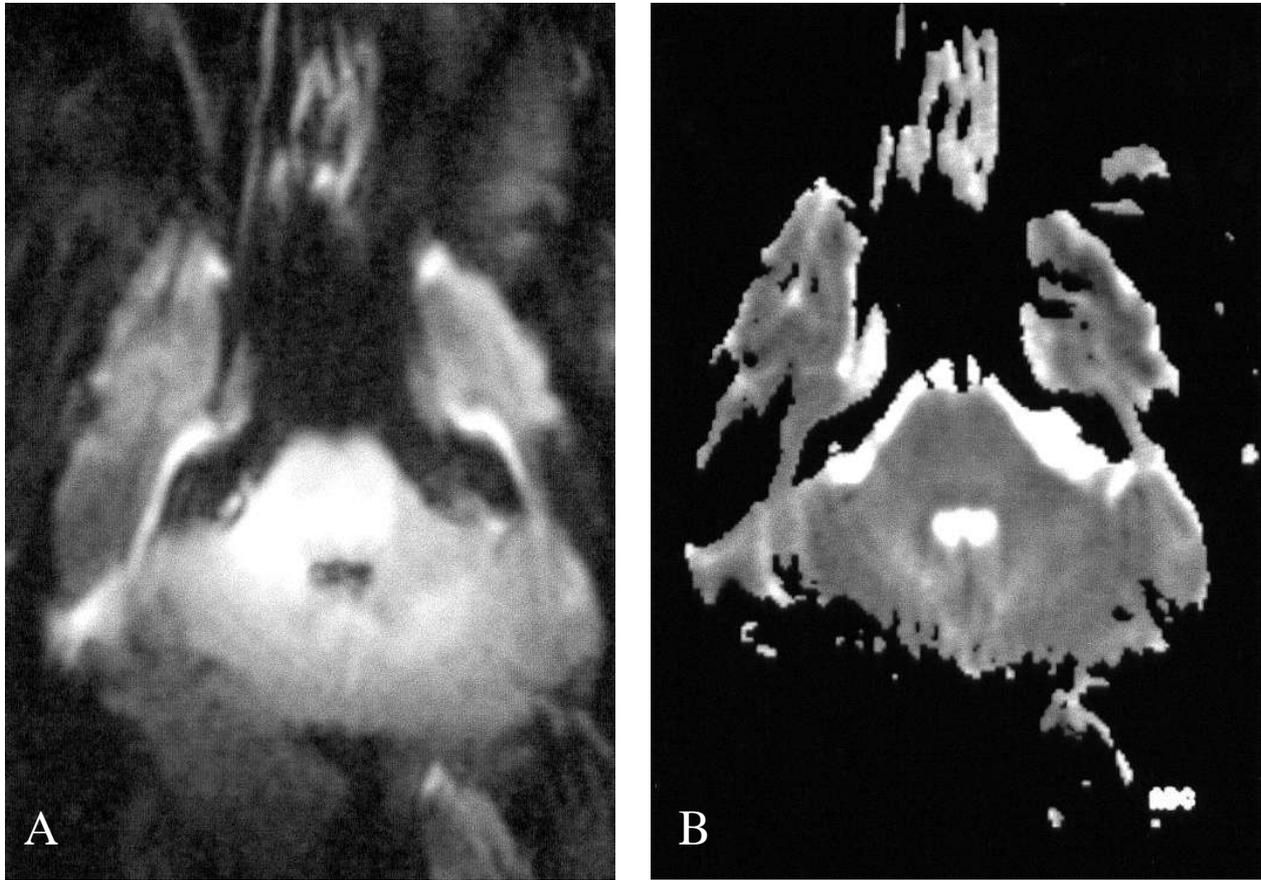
DWI. Both trace (A) and ADC map (B) reveals high signal intensity of lesion (ADC values in the right middle cerebellar peduncle:  $1.26 \times 10^{-3} \pm 13.2$ , in the pons:  $0.91 \times 10^{-3} \pm 8.1$ ).
